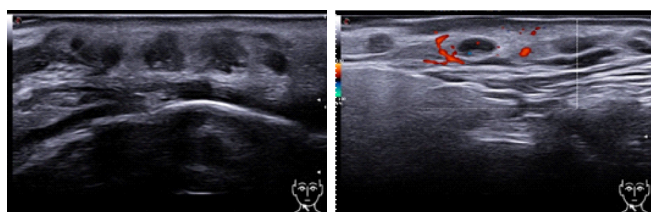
Echogram of soft tissues of the right maxillary region in B-Mode (1) and Color Doppler Mode (2).
